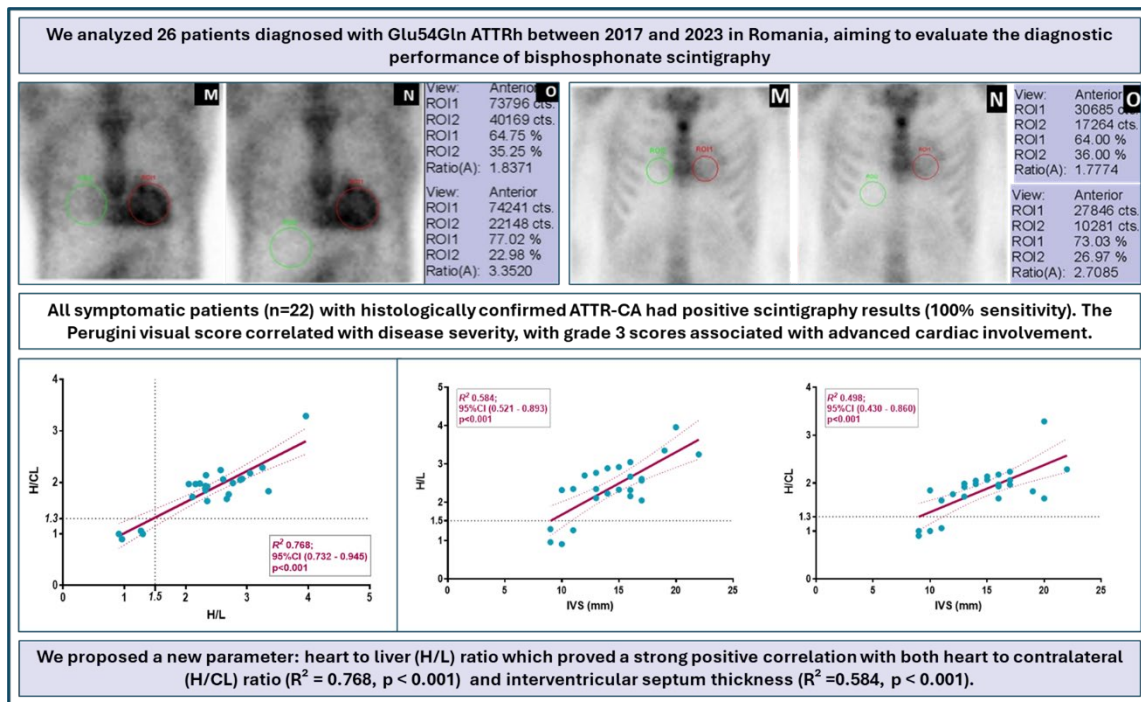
Graphical abstract of bisphosphonate scintigraphy results and heart/liver ratio (H/L), correlated with heart/contralateral region (H/CL) score and interventricular septal thickness (IVS).
